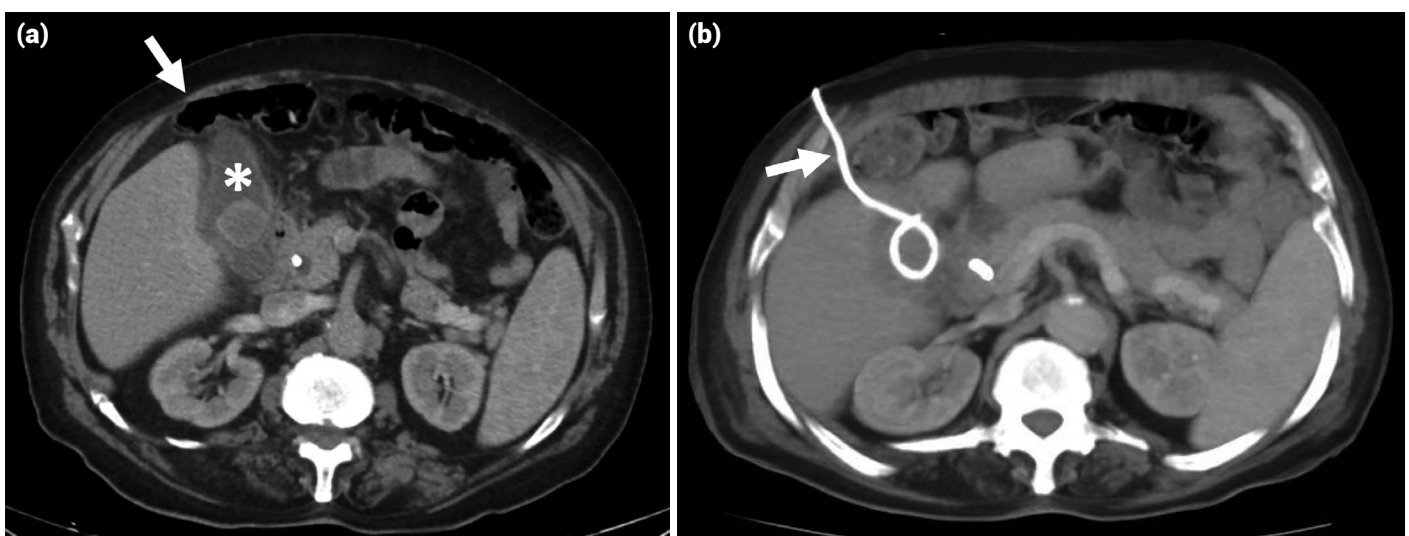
Transhepatic cholecystostomy for percutaneous biliary drainage. Interposition of large bowel loops (arrow) may complicate the procedure during bedside interventions if computed tomography images (a) are not available on site. Follow-up computed tomography (b) confidently rule out bowel transgression (arrow).
